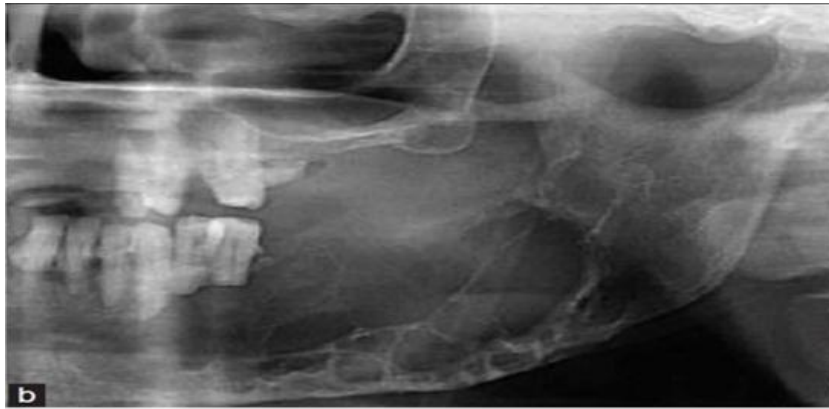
cropped panoramic radiograph showing spider-web type. (More et al, 2012)
